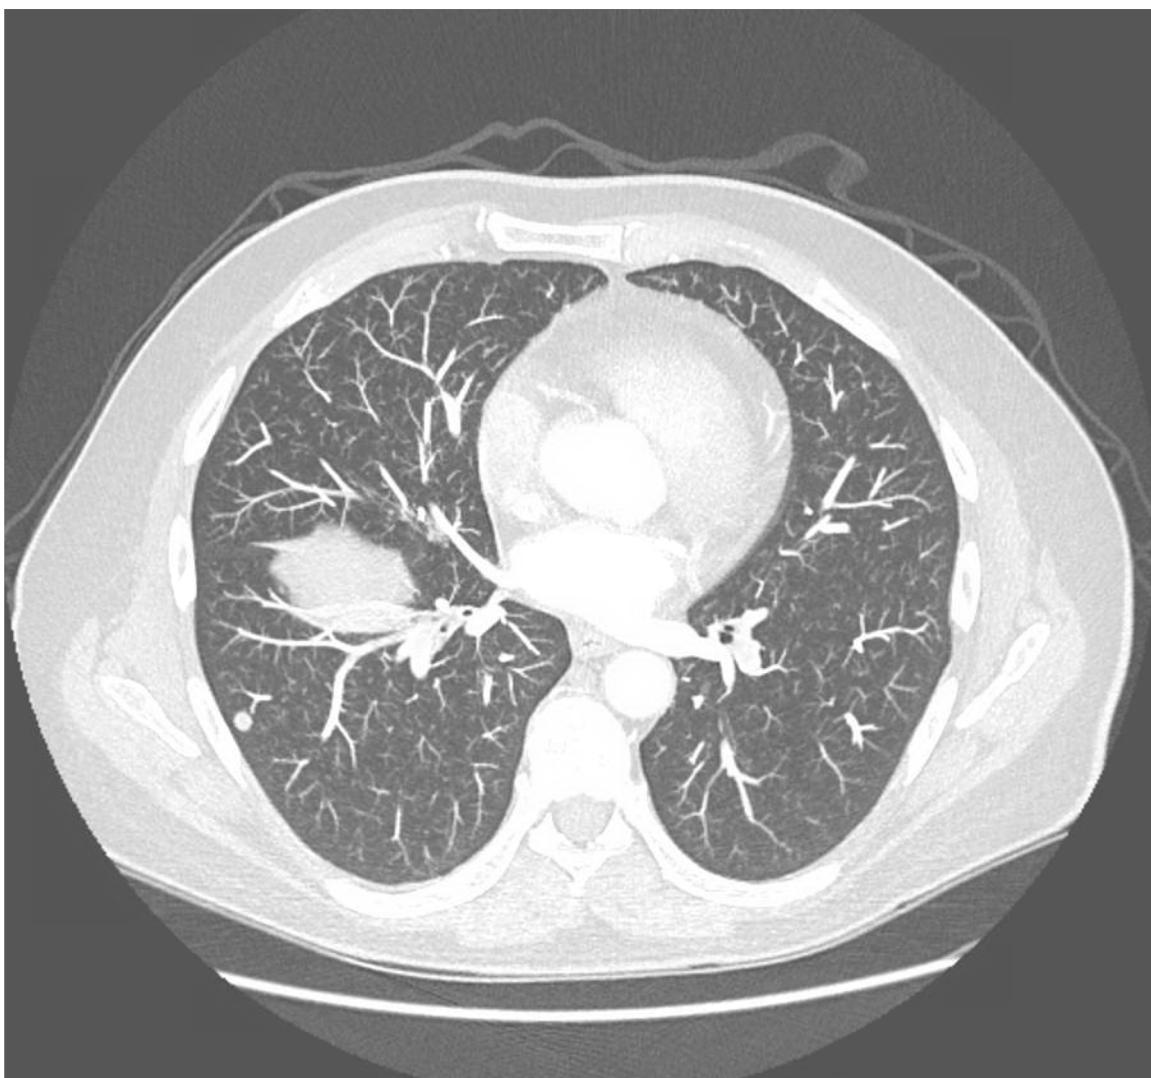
Stage IV rectal gist found on CT of the Abdomen and Pelvis with a small right pulmonary nodule suggestive of metastases to the lung.
